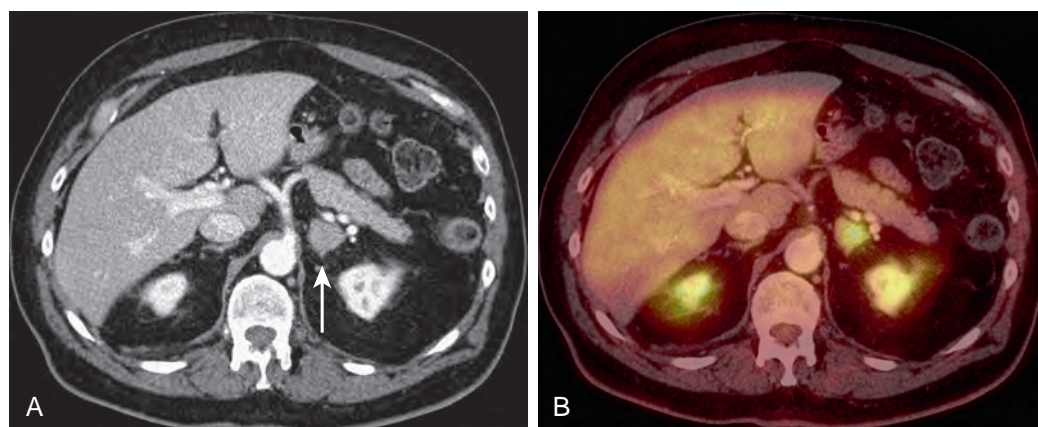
Adrenal adenoma. A. Contrast-enhanced CT demonstrating a 2.2-cm left adrenal nodule (arrow) that is incompletely characterized. B. Left adrenal nodule demonstrates increased FDG avidity, greater than that of the liver, on PET/CT. On resection, this was shown to be an adenoma; 5% of adrenal adenomas may show increased FDG uptake falsely positive for malignancy as was evident in this case.
